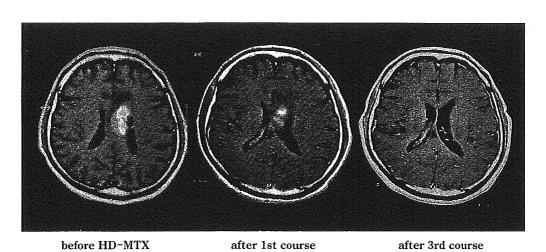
Gd-enhanced MRI of the patient before and after receiving a dose of $2.5\,\mathrm{g/m^2}$ MTX. The CSF concentration of MTX in this patient is shown in Fig. 2 (dashed line with*). The tumor completely disappeared after the third course of high-dose MTX chemotherapy.
